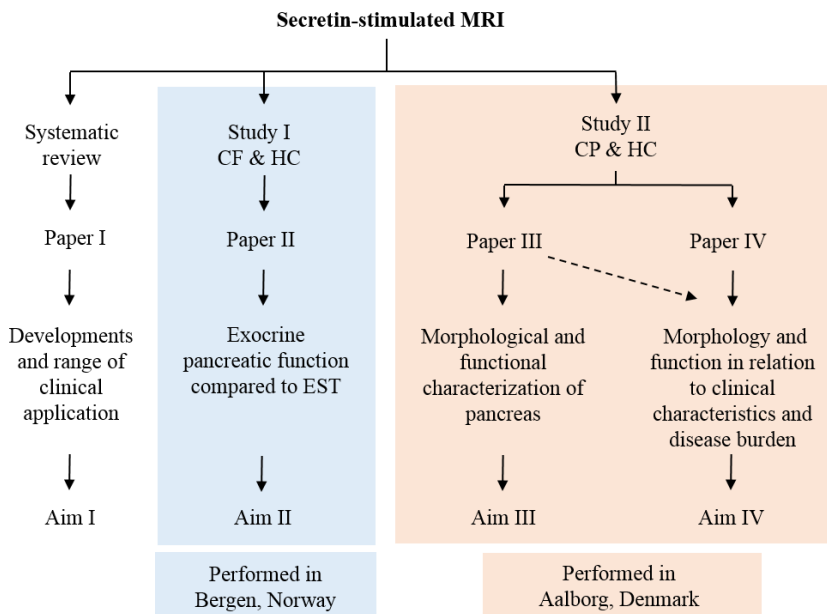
Overview of the aims from study I (Cystic fibrosis (CF) patients and healthy controls (HC)) and study II (Chronic pancreatitis (CP) patients and HC). MRI: magnetic resonance imaging; EST: endoscopic secretin test.
